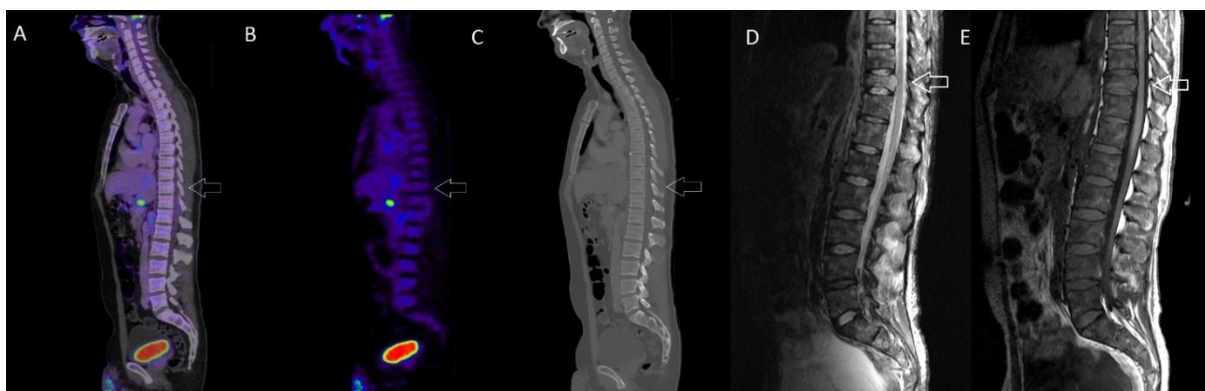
A 46-year-old man was diagnosed with cardia cancer (subcardial grade III). An initial FDG-PET/CT scan showed no bone metastases in the spine (A: PET/CT sagittal fused image; B PET sagittal view; C: CT sagittal view). 3
